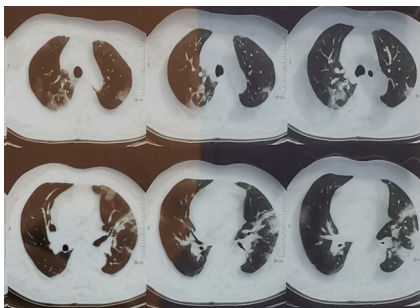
Chest CT images on February 15th. Chest CT images showed a few confluent ground-glass opacities about pleura in peripheral bilateral lungs. CT, computed tomography.
